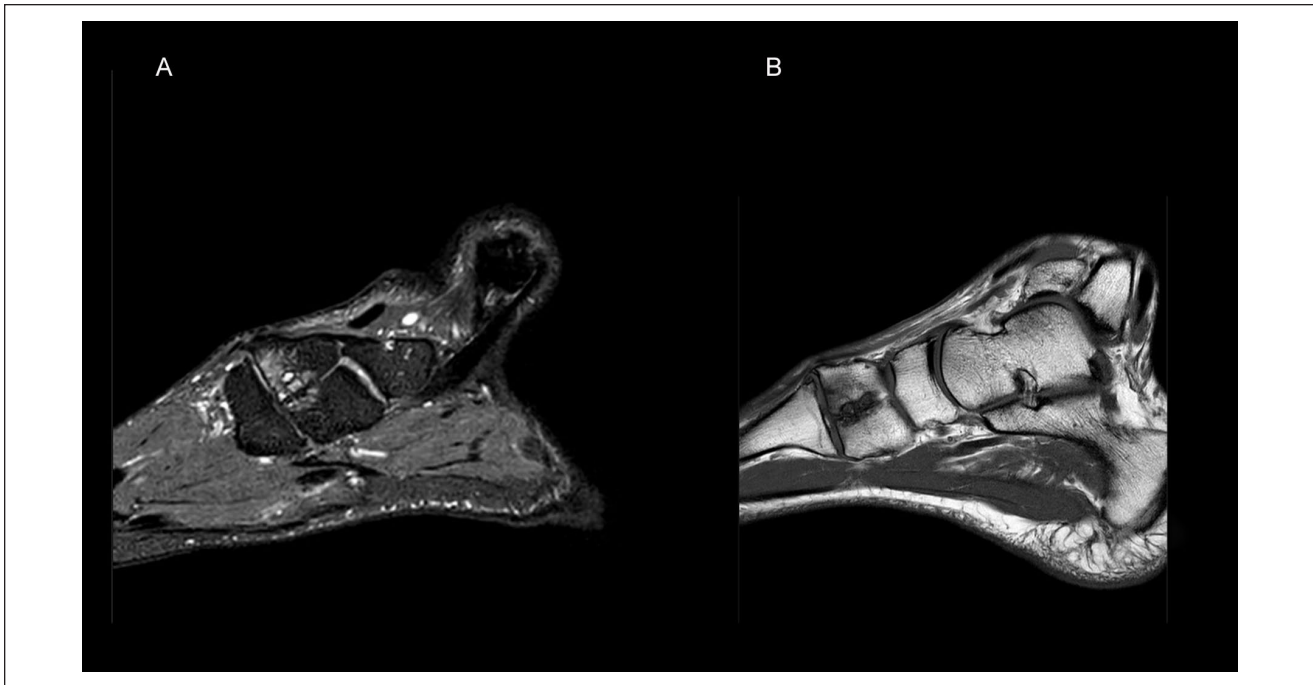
Magnetic resonance imaging 5 years after the incident showing a decreasing but still observable bone marrow edema of the 2 ossicles in T₂- (A) and T₁-weighted (B) sagittal scans, whereas the bone marrow edema in the first metatarsal completely resolved.
